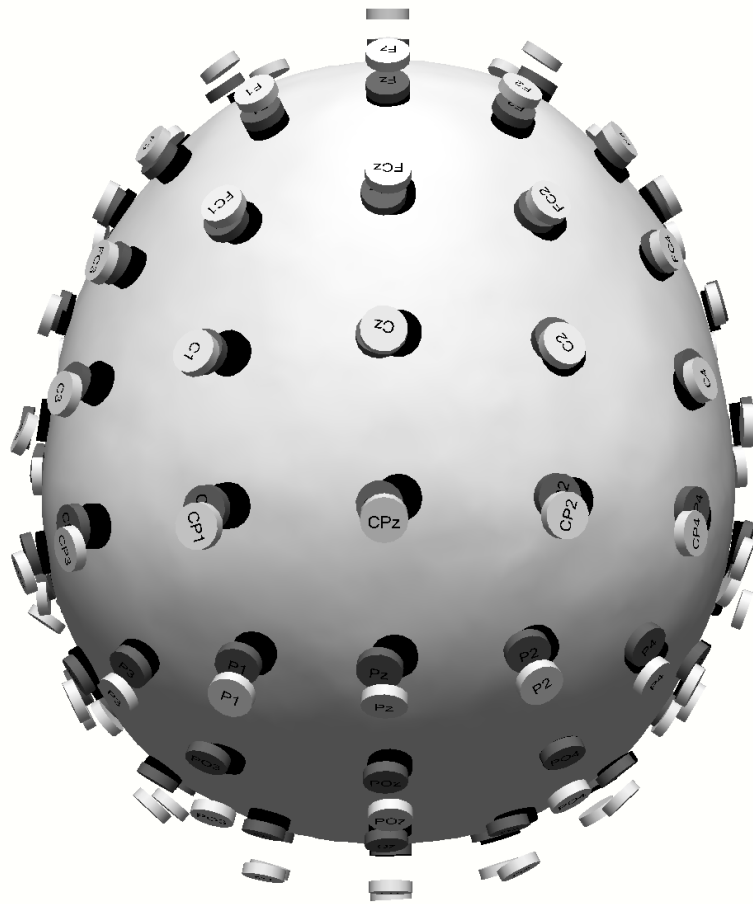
Extended 10-20 system electrodes for the ICBM-152 (light gray), the ICBM-152-A (dark gray), and the MRI-62-A (black), together with the skin surface of MRI-62-A.
